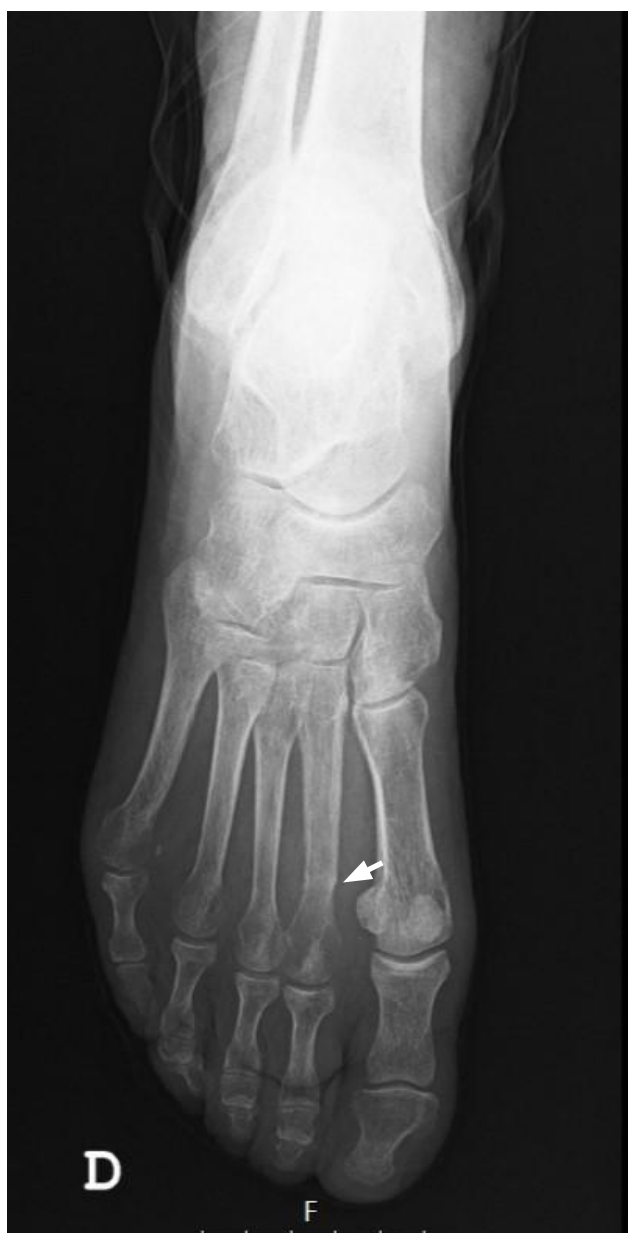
Right foot plain X-ray revealing a 2nd metatarsal bone fracture (white arrow).
